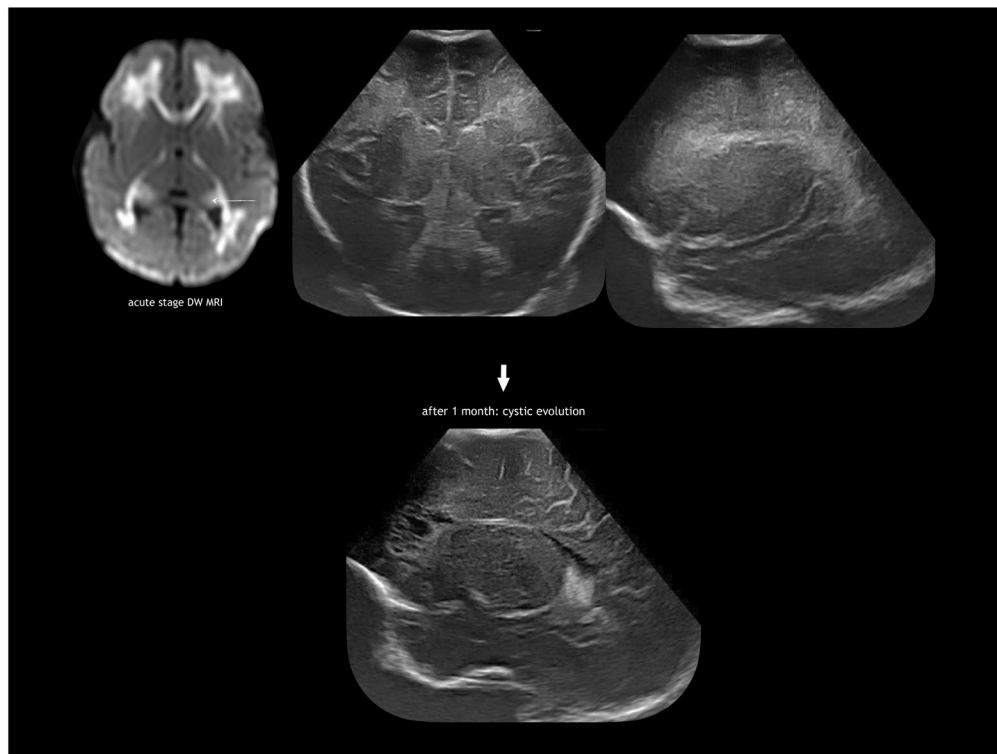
Enterovirus encephalitis-meningitis. Infant born late preterm, seizures caused by enterovirus meningitis at 2 weeks; cranial ultrasound images showing early hyperechoic white matter change evolving into cavitation mainly in the frontal lobes. Observe bilaterality and near symmetry. Observe restricted diffusion in the corresponding periventricular areas and network injury in pulvinar on DW MRI in the acute stage (arrow) as well as restricted diffusion in the corpus callosum, optic radiation, and posterior limb of the internal capsule. Abbreviation: DW MRI, diffusion-weighted magnetic resonance imaging.
